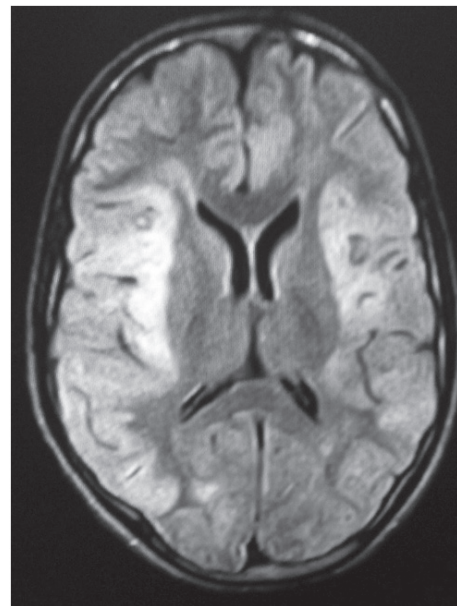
FLAIR image showing assymmetric high signal intensity involving bilateral insular cortices in a patient with acute encephalitis syndrome.
